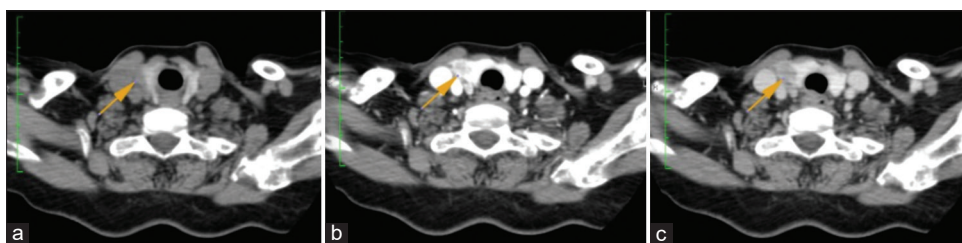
(a-c) 4D CT scan of neck showing lesion in the right inferior parathyroid gland in early intermediate and delayed phase
